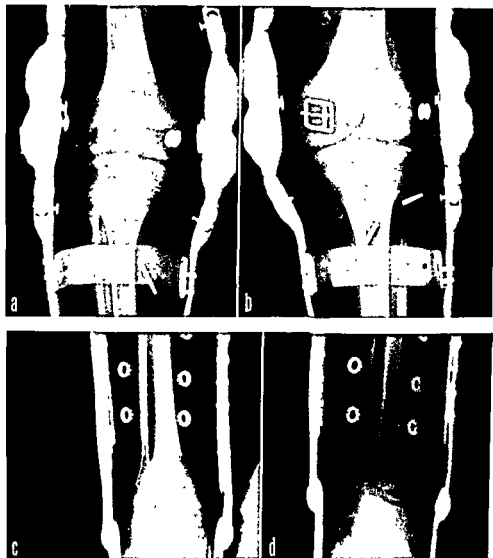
Case #3587 (age, 4, 1946). Same patient as Figure 9 (a and b) X-ray right ankle, low, ankle
